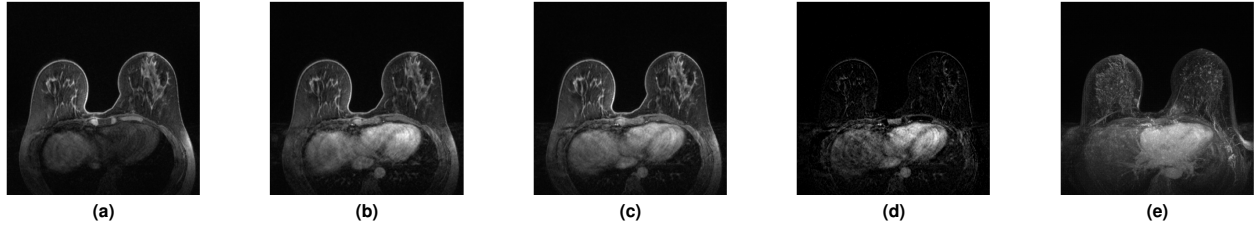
Example study from the NYU Breast MRI Dataset. Images present selected views from T1 fat-saturated series: (a) pre-contrast, (b) first post-contrast; (c) second post-contrast; (d) second post-contrast subtraction, and (e) maximum intensity projection. All images show breasts at the same level (slice in the middle of the volume), in axial projection. The presented sample study does not contain any suspicious enhancing masses or areas of ductal enhancement in either breasts and has been rated as BI-RADS 2 (benign). Note that in the process of filtering our dataset, we excluded subtraction and maximum intensity projection images, as those can be easily generated from pre- and post-contrast images only.
